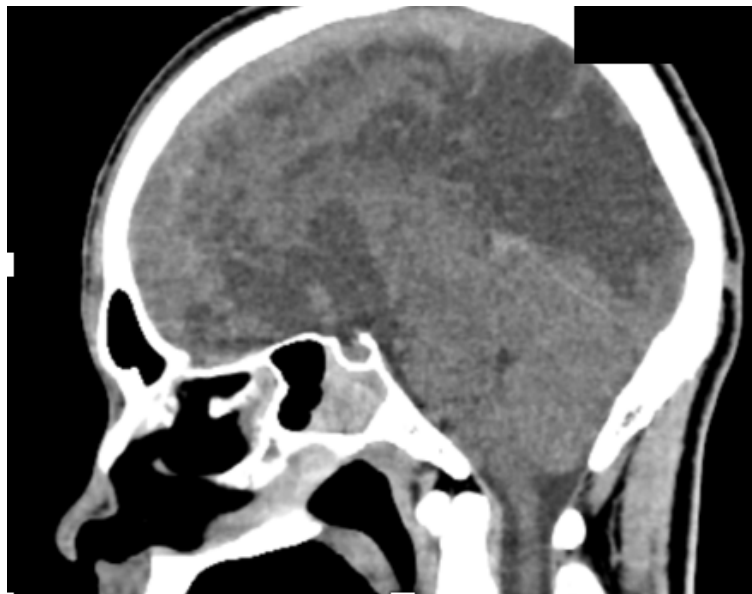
CT demonstrating occipital lobe hypodensities consistent with PCA territory infarction. This pattern is compatible with advanced uncus herniation within the proposed framework, involving distal P3–P4 cortical branches.
